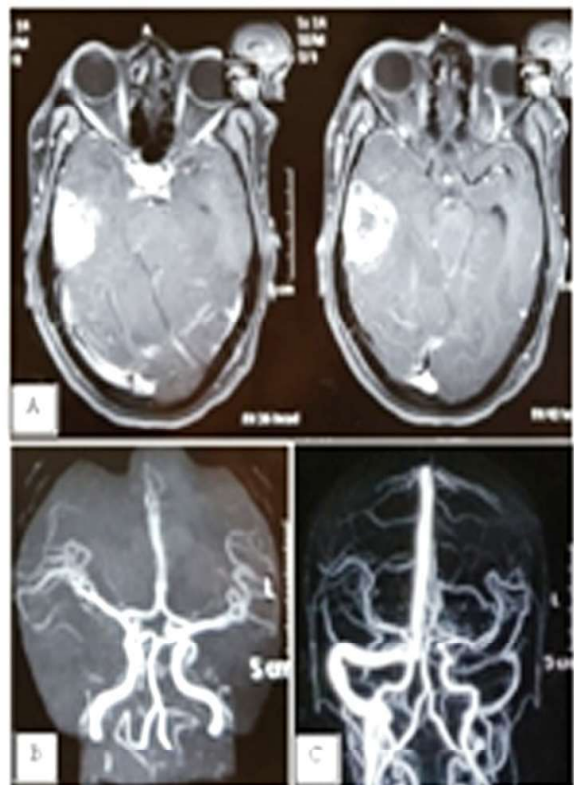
(A) MRI T1 contrast image showing enhancing lesion in right temporal lobe, (B) MR angio showing few prominent vessels in the mass lesion. (C) MR venography suggestive of normal study
